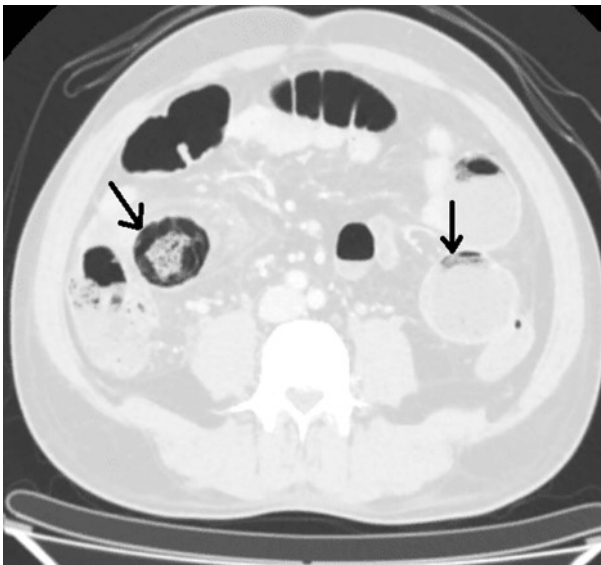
Blunt trauma - Pneumatosis intestinalis. Axial CT image shows circumferential pattern of pneumatosis intestinalis (Black arrows)
